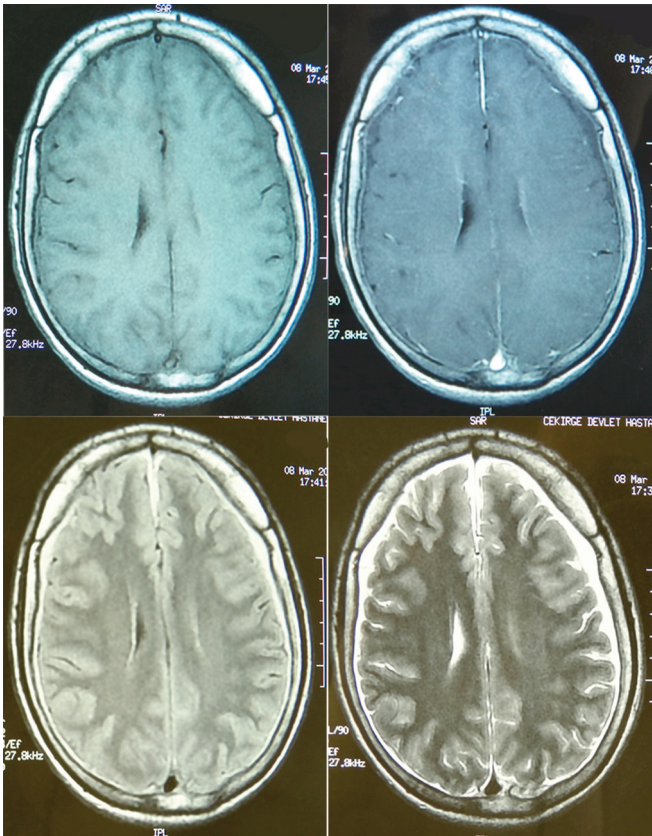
Brain MRI scan 6 days after spinal anesthesia showing bilateral subdural haematoma.
